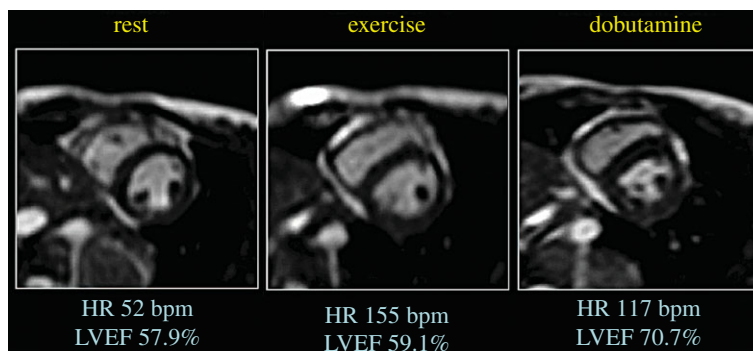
Augmentation of cardiac output during exercise as compared with dobutamine. As compared with rest, cardiac output increases substantially during exercise and modestly with dobutamine. Short-axis cine magnetic resonance images taken at end-systole demonstrate that augmentation during exercise is due to an increase in end-diastolic volumes and a reduction in end-systolic volumes. This is distinctly different from the response to dobutamine, in which the end-diastolic volume is reduced and the end-systolic volume is markedly reduced (seen as a pronounced reduction in end-systolic area in the figure). These differences are more clearly seen in the accompanying video (electronic supplementary material). (Online version in colour.)
